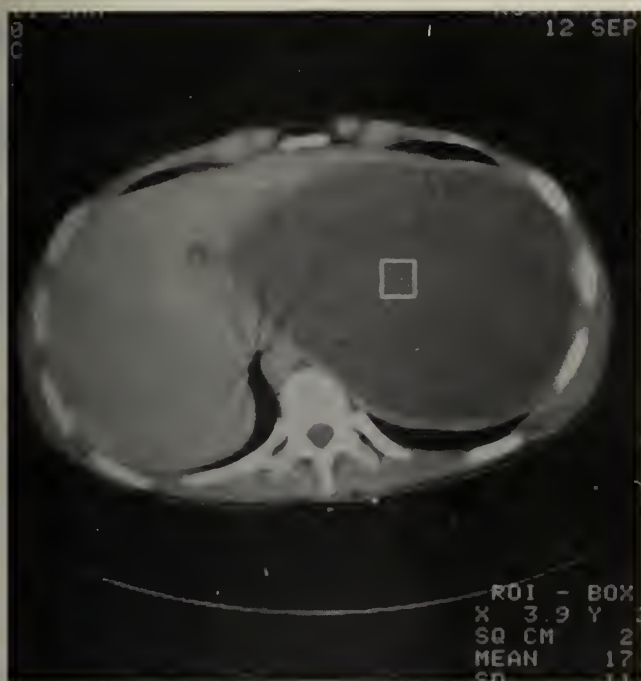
CT scan of the abdomen (transverse section) revealing a large cystic lesion which was thought to be of hepatic origin.
